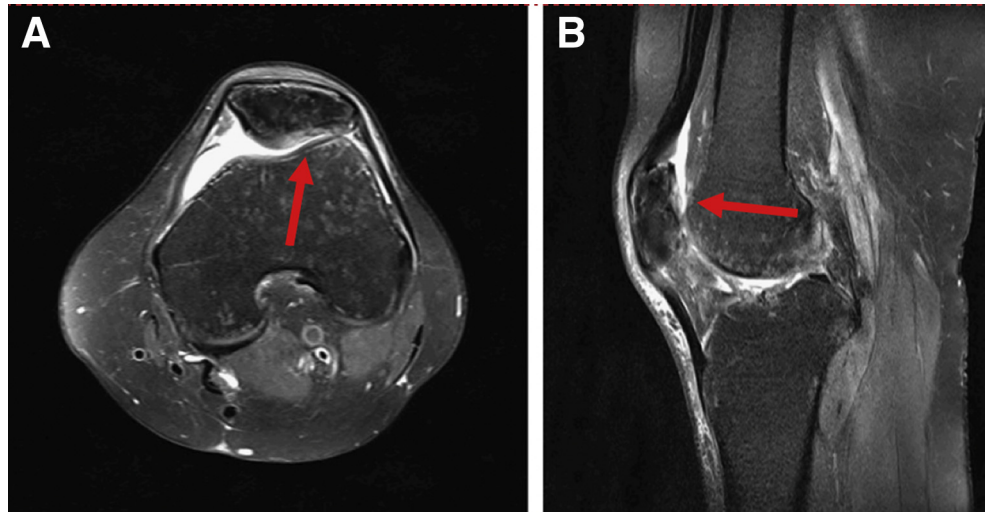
Preoperative magnetic resonance imaging demonstrating a retropatellar full-thickness cartilage lesion in the sagittal (A) and axial (B) planes.
